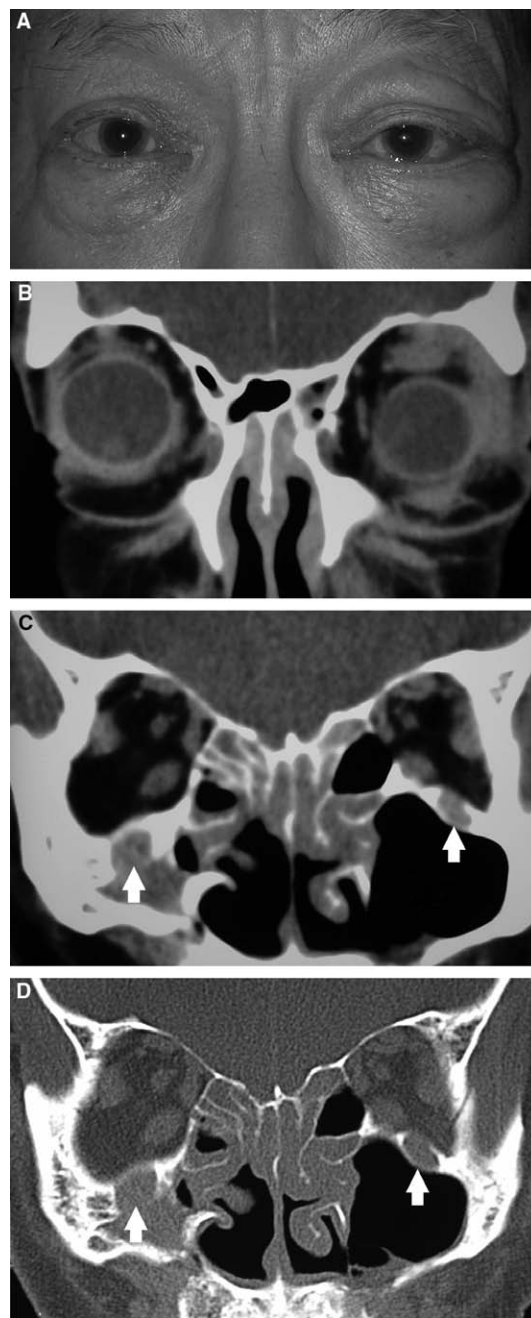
Case 4. Lacrimal gland swelling, cervical lymphadenopathy, asthma, chronic rhinosinusitis, enlarged infraorbital nerves, developed diffuse large B-cell lymphoma and died from lymphoma. A, A 51-year-old man first presented in 1991 with a year of left lacrimal gland swelling, cervical lymphadenopathy, asthma and chronic sinusitis, and an urticarial rash. He had been labeled as Sjögren disease but had negative serology. Biopsy of the left lacrimal gland was diagnosed as reactive lymphoid hyperplasia. He responded well to oral steroids and chlorambucil. B, C, and D, CT scans showed lacrimal gland disease with some mild enlargement of some EOMs, rhinosinusitis and changes from previous sinus surgery, and grossly enlarged infraorbital nerves and canals on each side (arrows). He returned in 2008 with increasing bilateral proptosis. He was rebiopsied and found to have large numbers of IgG4+ plasma cells. He was treated with oral prednisolone and methotrexate with a good response. Two years later, he developed diffuse large B-cell lymphoma, initially arising in lymph nodes, and died from his disease 18 months later.
